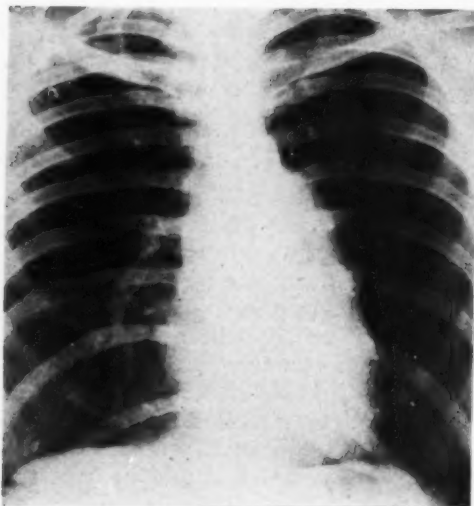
Roentgenogram of chest made Sept. 17, 1935. Note the thin, curved shadow overlying the arch of the aorta.
